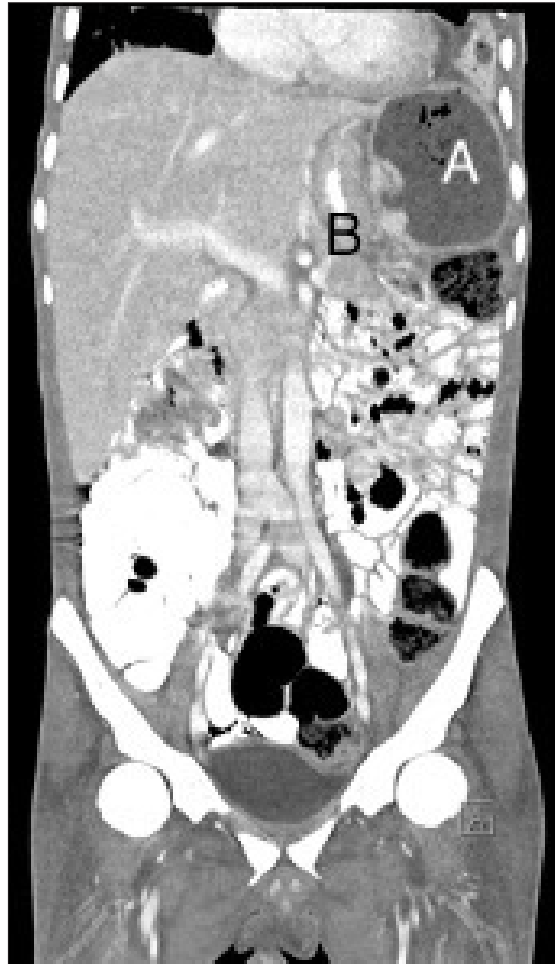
CT scan abdomen, coronal view A: spleen with liquefaction and necrosis, B: stomach.
